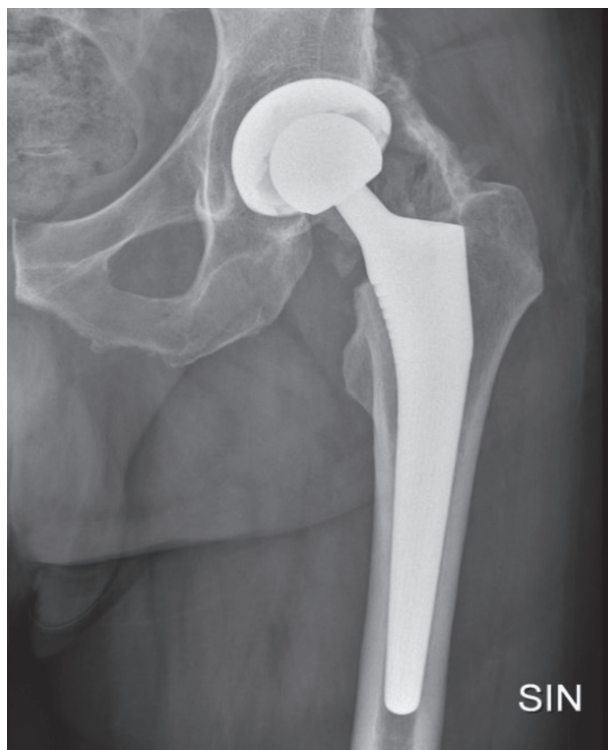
One year post-operative xray showing HO Class IV Brooker's
